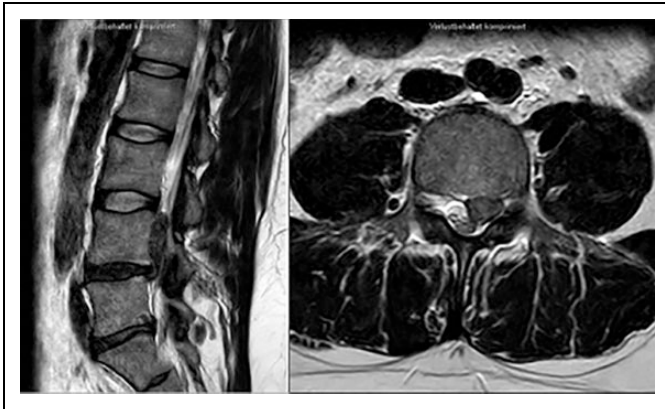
Preoperative MRI of a 45 year-old man, showing cranially migrated sequestration L4/5 on the left side.
